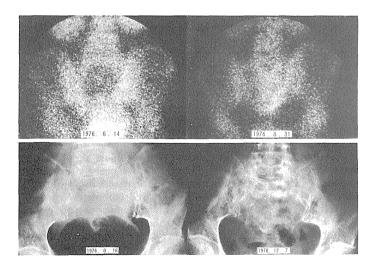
A 44-year-old woman with sacral bone metastasis of cervical cancer (case 12). Upper photographs are the scintigrams of the pelvis. Before treatment, a round area of negative uptake of isotope is evident in the sacral bone (left). After four courses, the defect disappeared (right). Re-ossification had not as yet occurred, as shown in the bone roentogenogram (left, below), but it did occur three months after the fourth course (right, below).
